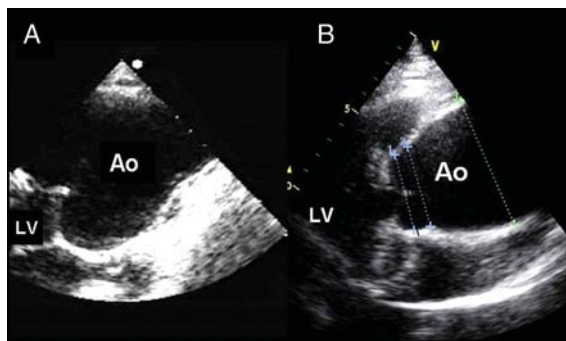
Parasternal long-axis view by transthoracic echocardiography. (A) Annuloaortic ectasia with pyriform morphology. (B) Ascending aorta aneurysm located in the upper part of the sinotubular junction.
